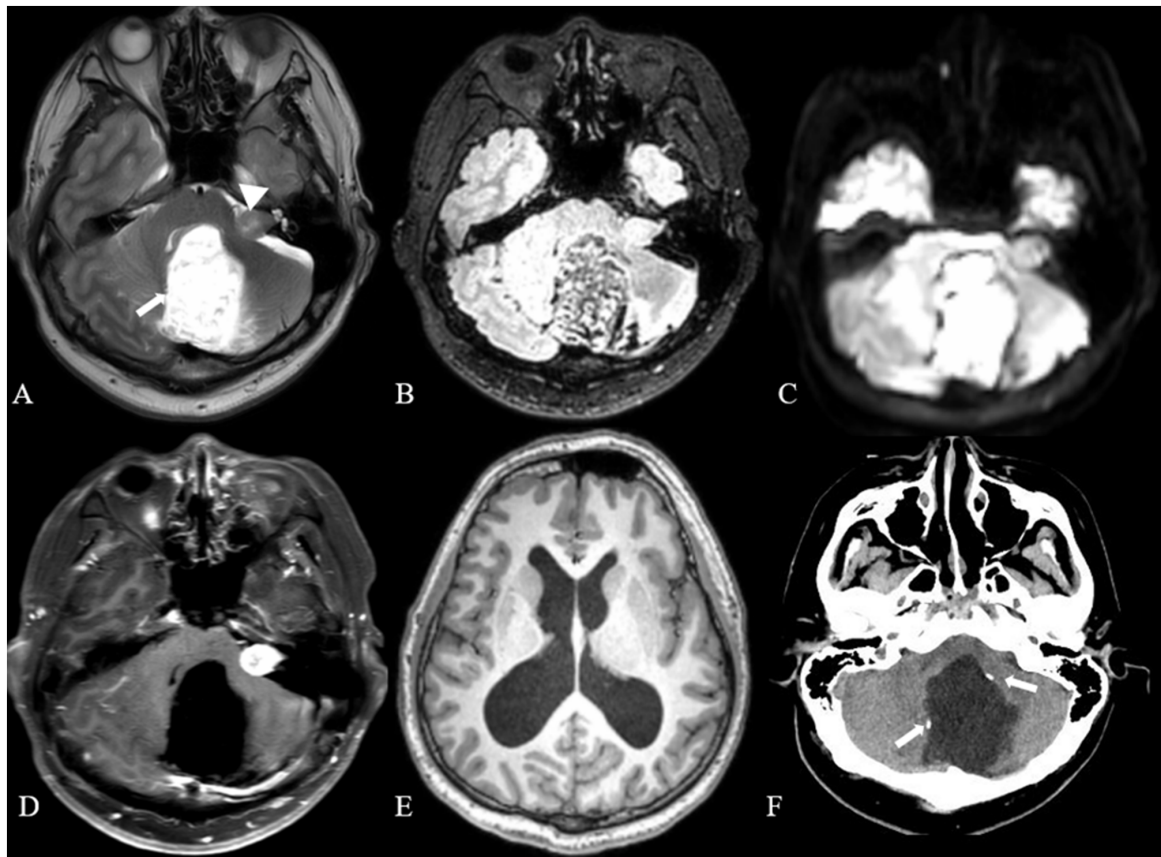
Preoperative images. (A) Axial T2-weighted MR image revealed a large, left cerebellar hemisphere cystic lesion (arrow), along with a solid lesion in the left CPA region (arrowhead). (B) In the axial fluid-attenuated inversion recovery MR image, the left cerebellar hemisphere cystic lesion is dark and heterogeneous. (C) On axial diffusion-weighted MR imaging, the left cerebellar hemisphere cystic lesion was displayed with a markedly high signal. (D) The axial T1-weighted contrast-enhanced MR image displayed the left cerebellar hemisphere cystic lesion without enhancement, but the solid lesion in the CPA region was homogeneously enhanced. (E) The fourth ventricle outflow was decompressed and axial T1-weighted MR imaging revealed supratentorial hydrocephalus. (F) Axial CT scan revealed the partial calcification around the cystic wall and enlargement of the left internal auditory canal compared to the right (arrows). CPA, cerebellopontine angle; MR, magnetic resonance.
